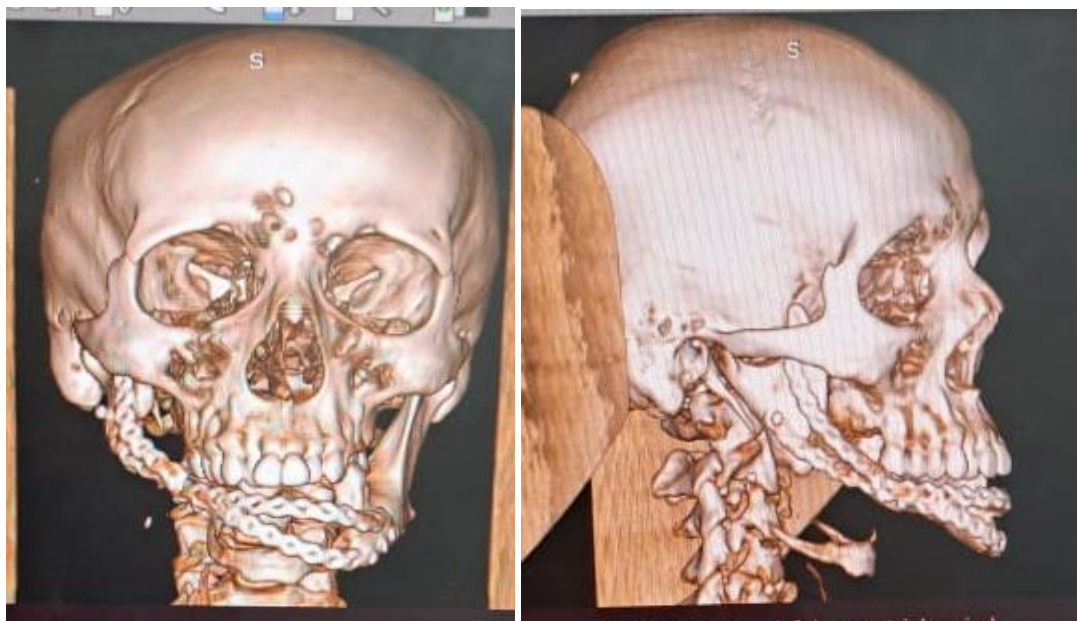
3D reconstruction image of facial CT scan after right mandibulectomy
